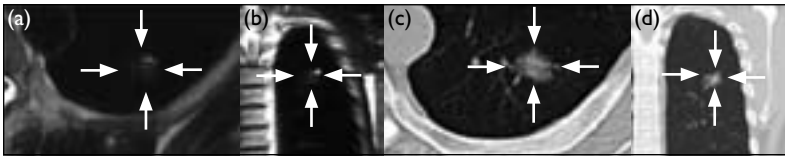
(a) Axial T1-weighted image shows an irregular focal lesion with increased signal in upper lobe of the left lung. (b) Coronal T1-weighted image again shows the left upper lobe lesion with a tiny hyperintense focus. (c, d) Corresponding axial and coronal computed tomographic scans (lung window) demonstrate the patchy lesion with a spiculated outline
